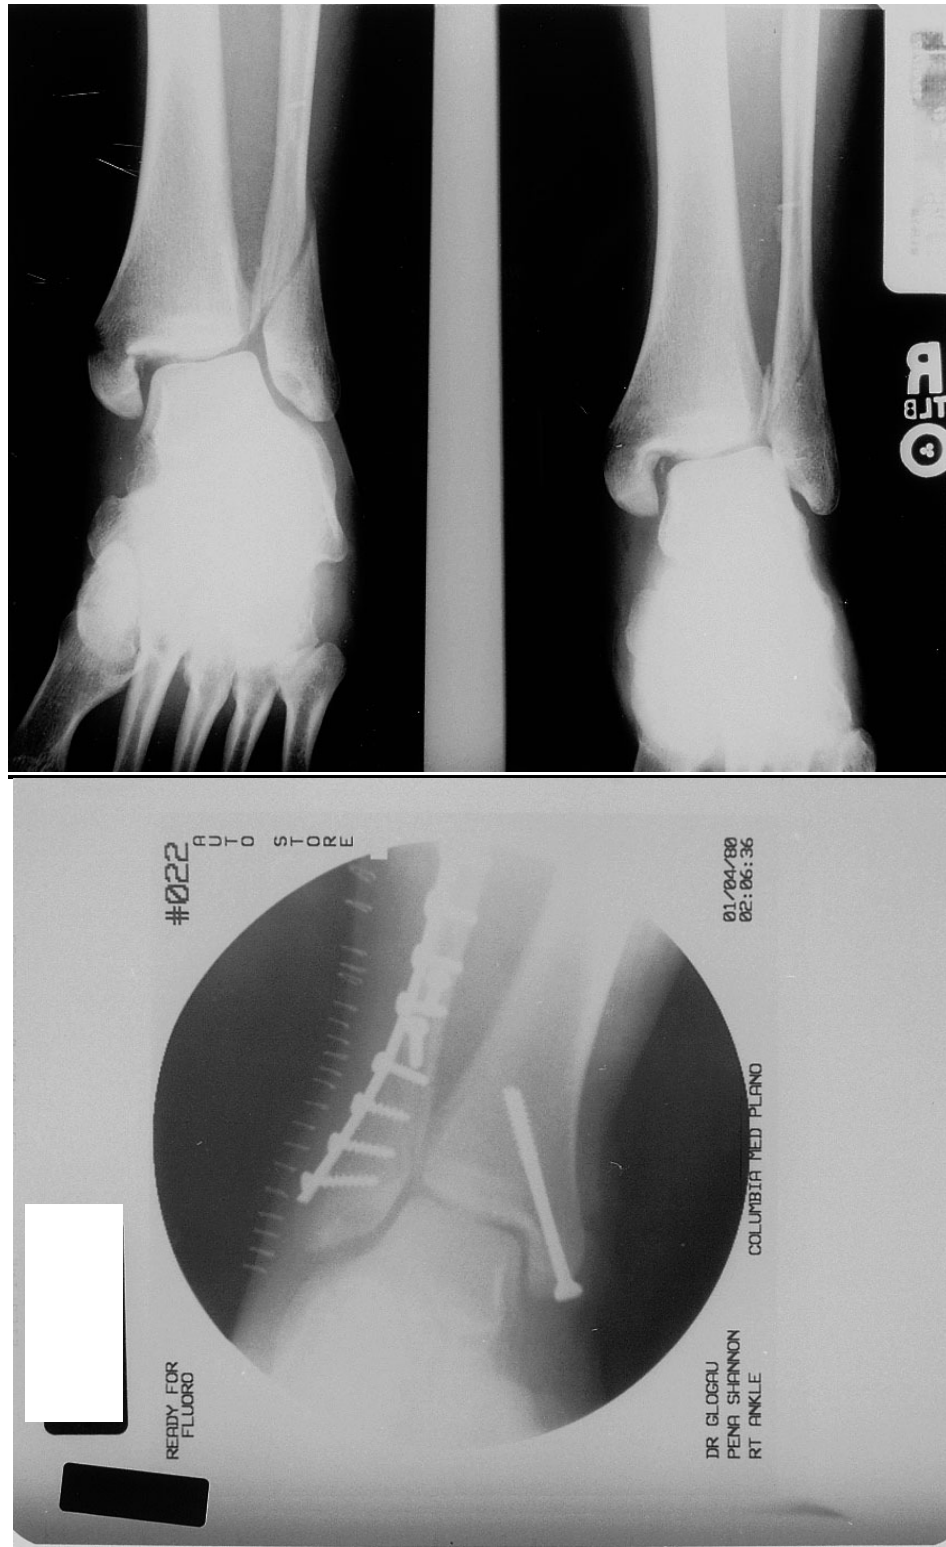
Radiographs from PWC File 16.
